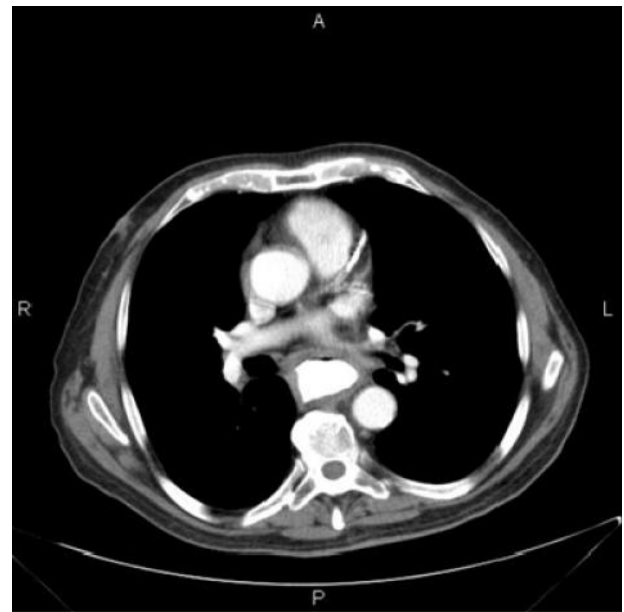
Post procedure CT
